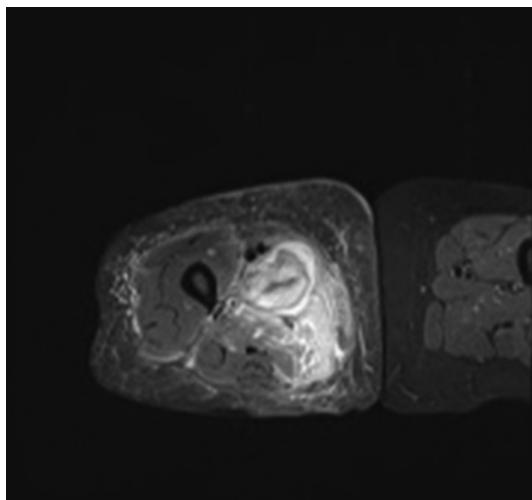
Axial T2-weighted fat-suppressed magnetic resonance imaging of the right thigh showing heterogeneous signal intensities in the adductor muscles. Edema of the adductor muscles and subcutaneous tissue is seen.
